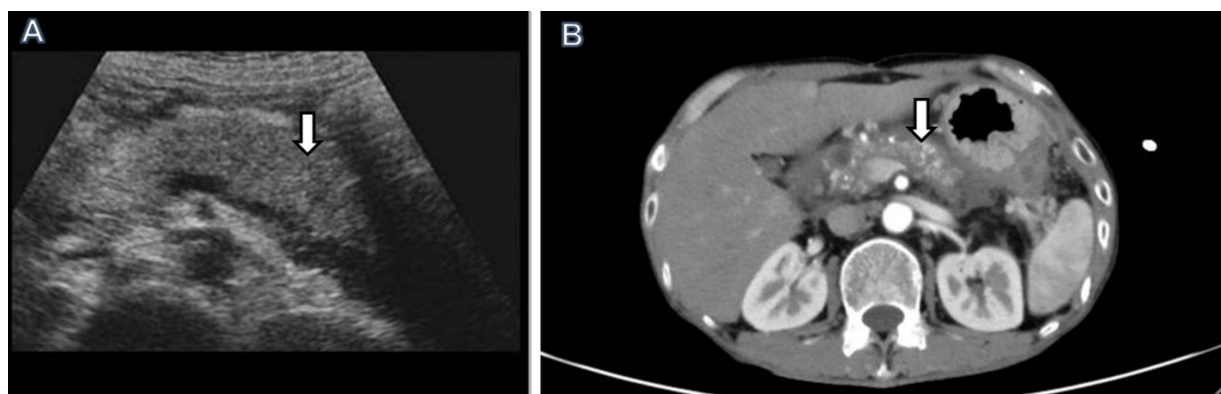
Ultrasound (A) and CT (B) images showing parenchymal pancreatic necrosis (arrow) in a 65-year-old patient.
